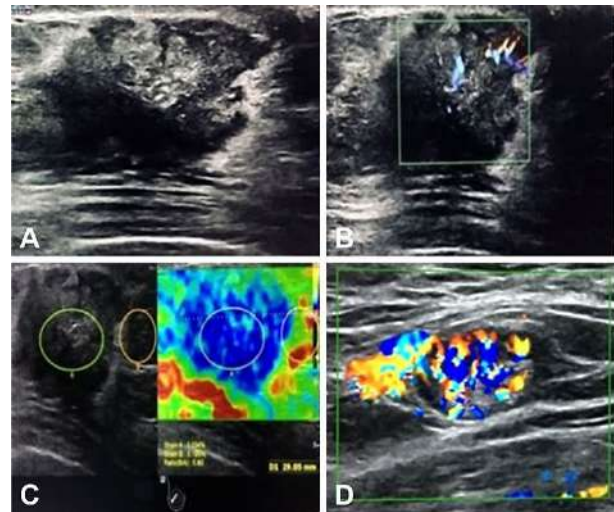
Ultrasound examination of a 78-year-old patient, right breast, upper and external quadrant: hypoechoic lesion, irregular, with microlobulations (A), and increased vascular signal (B), increased elastographic value – strain ratio 5.8 (C), axillary pathological adenopathy (D). Anatomopathological characteristics: invasive breast carcinoma; ER-positive 80%; PR-positive 60–70%; HER2-negative (score 0); Ki67 index 10%; luminal A subtype. ER: Estrogen receptor; HER2: Human epidermal growth factor receptor 2; PR: Progesterone receptor.
